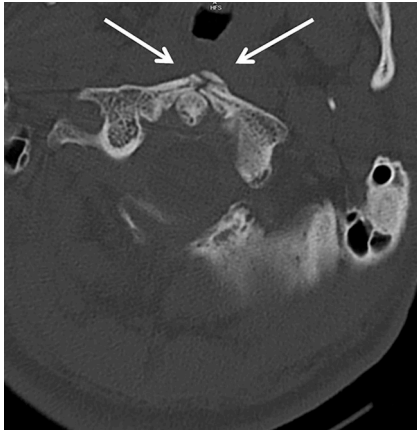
Trauma CT-scan: C1 fracture (arrows).
